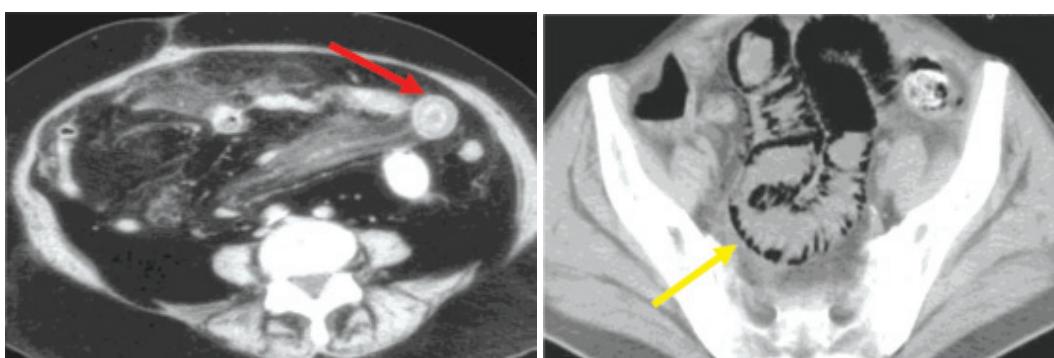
SB strangulation, a serious complication of SBO; axial CT views show pneumatosis intestinalis (yellow arrow), and target sign (red arrow) of ischemic small bowel loop.
